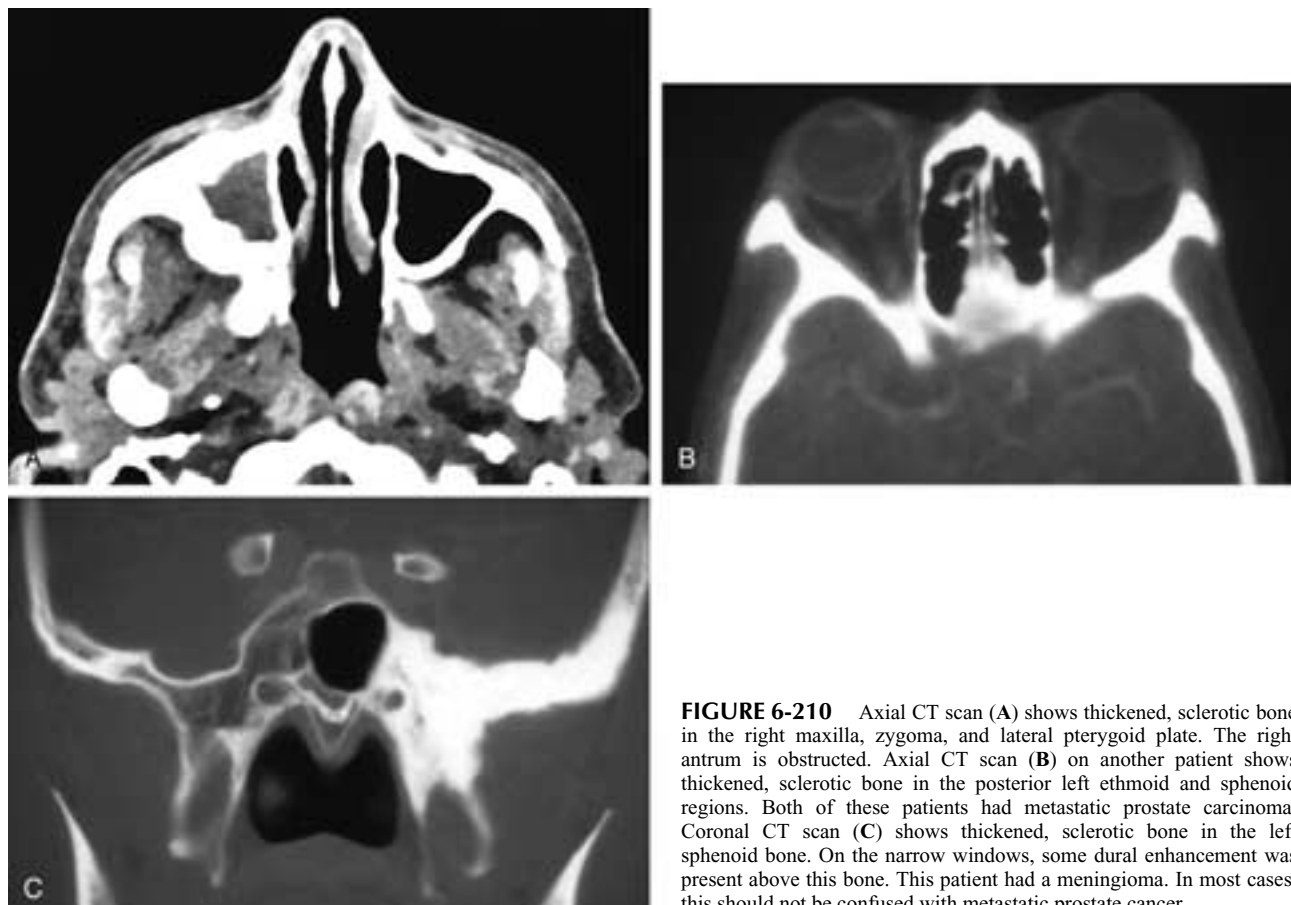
Axial CT scan (A) shows thickened, sclerotic bone in the right maxilla, zygoma, and lateral pterygoid plate. The right antrum is obstructed. Axial CT scan (B) on another patient shows thickened, sclerotic bone in the posterior left ethmoid and sphenoid regions. Both of these patients had metastatic prostate carcinoma. Coronal CT scan (C) shows thickened, sclerotic bone in the left sphenoid bone. On the narrow windows, some dural enhancement was present above this bone. This patient had a meningioma. In most cases, this should not be confused with metastatic prostate cancer.
